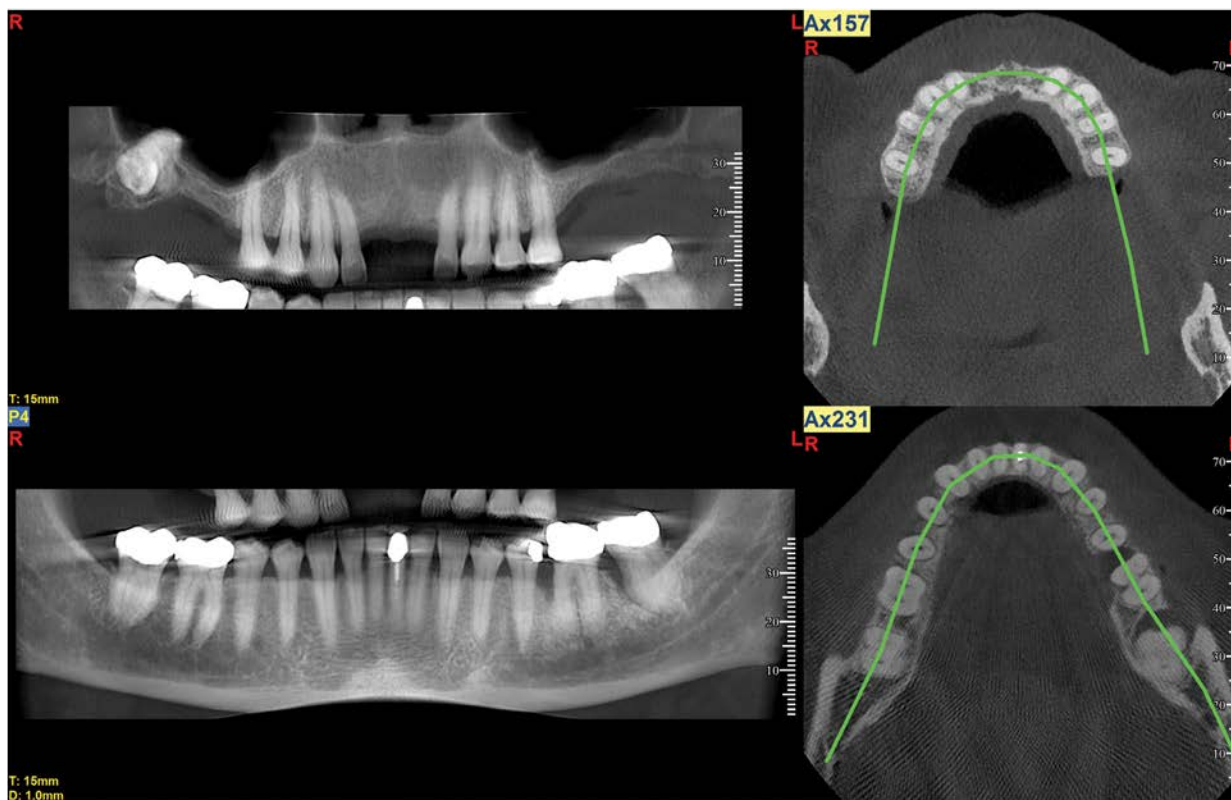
CBCT images of the patient, confirming advanced ridge resorption of the facial plate at the proposed implant sites, and dictating the need for ridge augmentation prior to implant placement.
